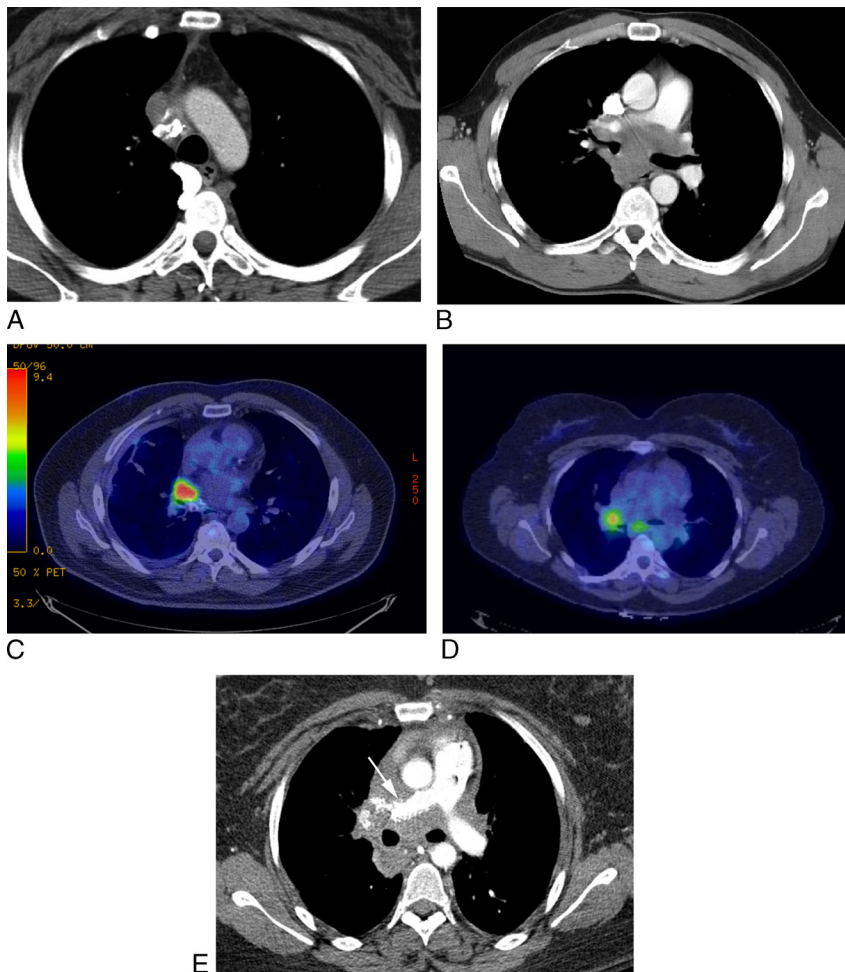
Radiographic patterns in fibrosing mediastinitis. A, Localized, calcified mass lesion. B, Diffuse, noncalcified mediastinal infiltration. C and D, PET scans demonstrating increased fluorodeoxyglucose (FDG) uptake of representative FM lesions. E, Representative CT scan demonstrating pulmonary artery compression by FM lesion (white arrow).
